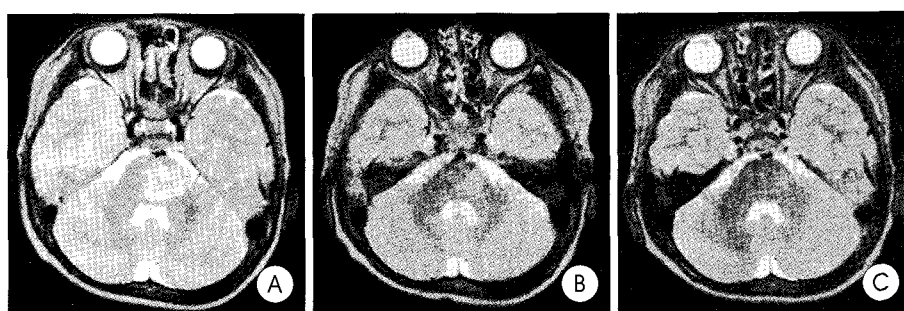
A : Brain T2-weighted magnetic resonance(MR) imaging demonstrates diffuse intrinsic tumor. B : One month after fractionated stereotactic radiotherapy, the follow-up MR image reveals decrease in size of the tumor. C : Three months after FSRT, MRI shows complete response of the tumor.
